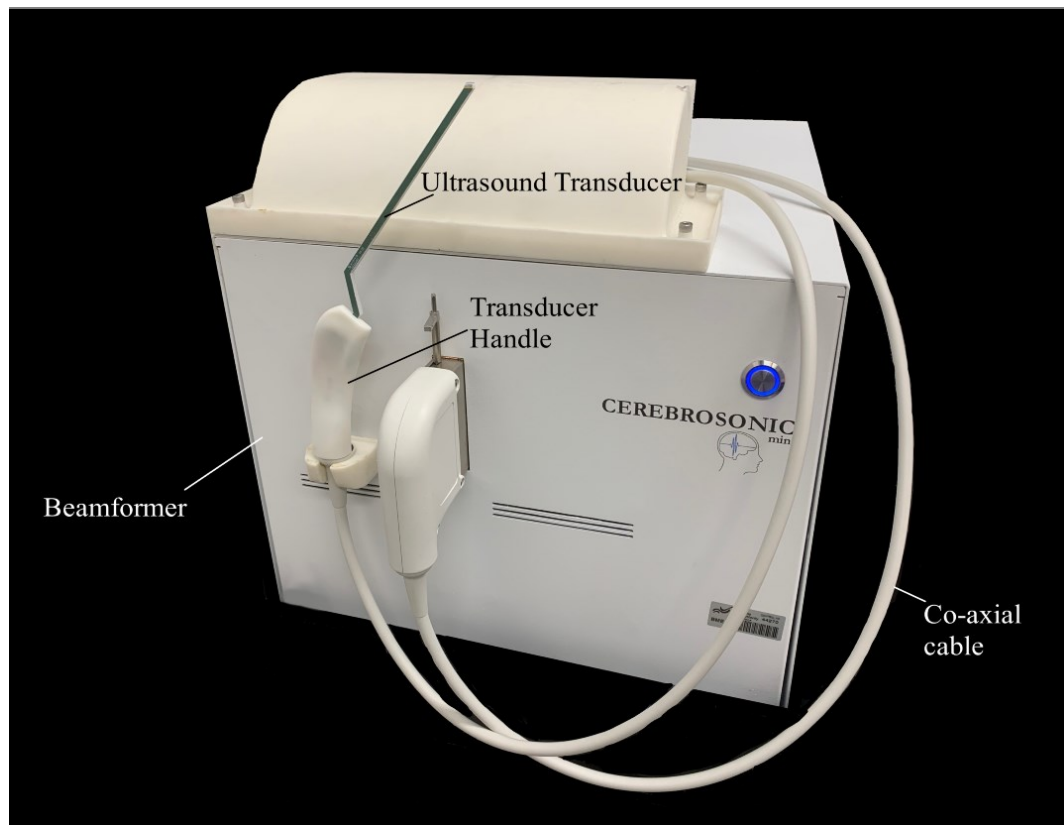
The hardware of an ultrasound system including the beamformer, co-axial cable, and ultrasound endoscope.
